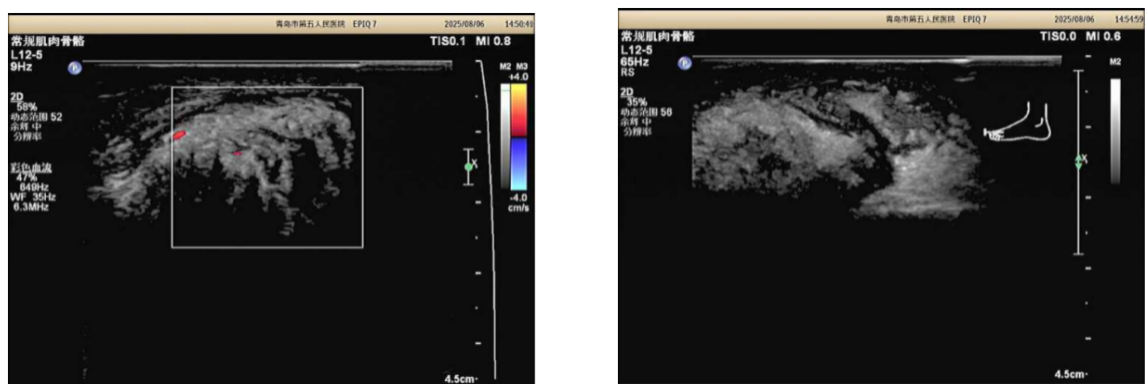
Ultrasonography of the left foot. (A) Mixed echogenicity measuring approximately 8×2.8 cm at the first MTP joint with indistinct margins and increased Doppler vascularity. (B) Arc-shaped hyperechoic deposits on the cartilage surface (“double contour sign”), synovial thickening up to 9.5 mm with irregular projections, and multiple punctate hyperechoic foci consistent with tophaceous material.
